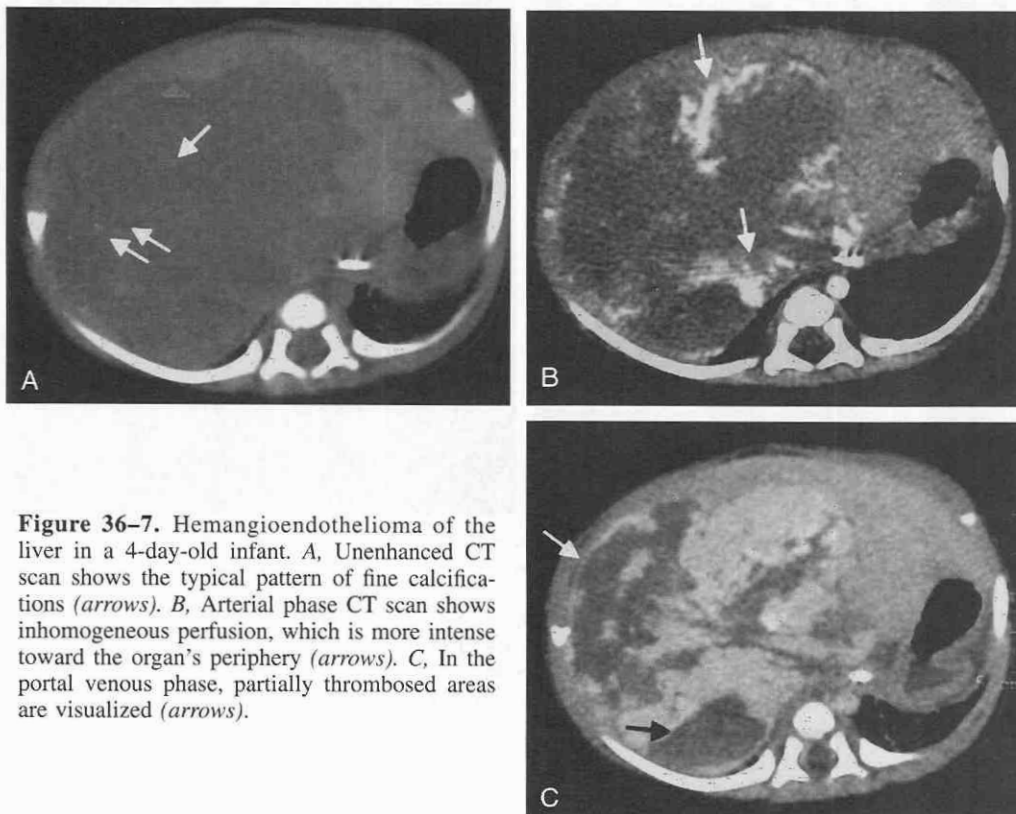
Hemangioendothelioma of the liver in a 4-day-old infant. A, Unenhanced CT scan shows the typical pattern of fine calcifications (arrows). B, Arterial phase CT scan shows inhomogeneous perfusion, which is more intense toward the organ's periphery (arrows). C, In the portal venous phase, partially thrombosed areas are visualized (arrows).
